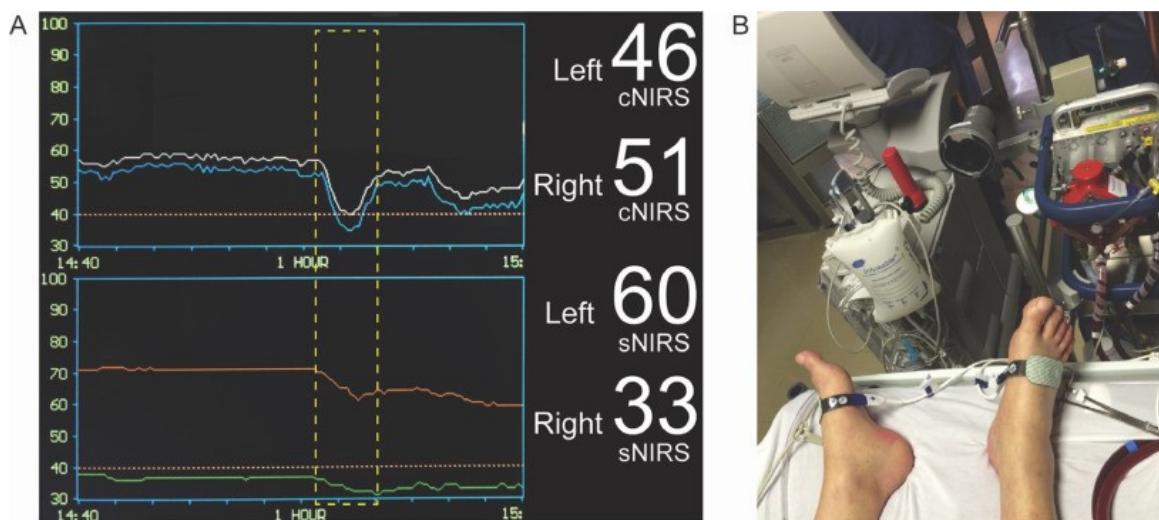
Asymétrie entre les valeurs d'oxymétrie somatique (60% vs 33%) chez un patient post CEC en lien avec une canulation fémorale droite. (Figure tirée avec permission de Denault, A., Ali, M. S., Couture, E. J., Beaubien-Souigny, W., Bouabdallaoui, N., Brassard, P., ... & Deschamps, A. (2019). A practical approach to cerebro-somatic near-infrared spectroscopy and whole-body ultrasound. Journal of cardiothoracic and vascular anesthesia, 33, S11-S37.)[97]
